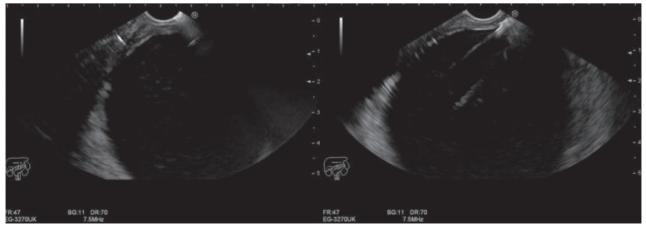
Endoscopic ultrasound image of a pseudocyst punch with a 19 Ga Boston needle.
